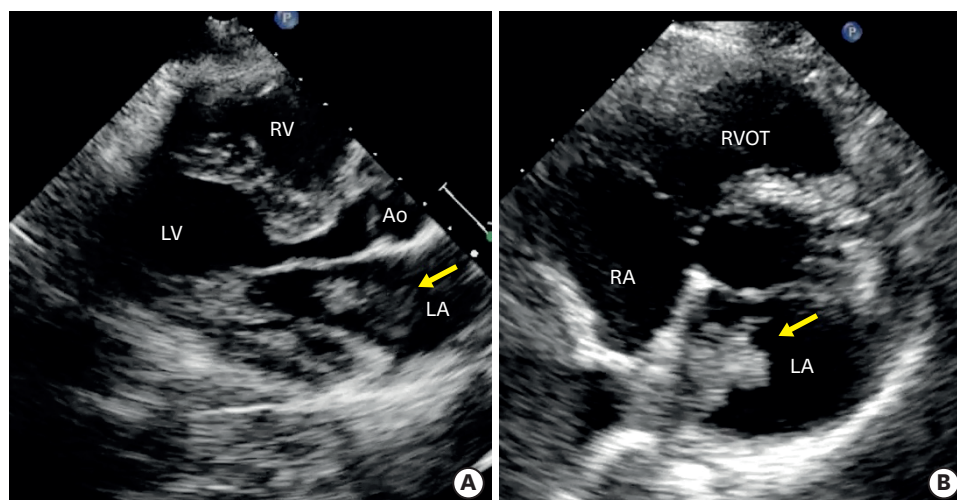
Transthoracic echocardiogram. (A) Parasternal long-axis view demonstrating a moving mass in the LA. (B) Parasternal short-axis view showing the LA mass, which had irregular edges and appeared adherent to the interatrial septum / posterior wall of the LA. Ao: aorta, LA: left atrium, LV: left ventricle, RA: right atrium, RV: right ventricle, RVOT: right ventricle outflow tract.
